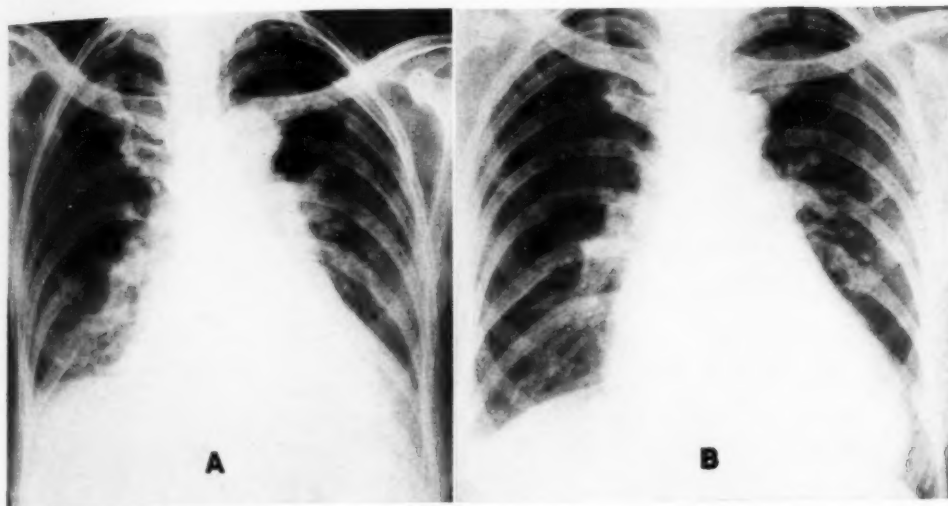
Pulmonary congestion. A. Roentgenogram with normal pressure. B. Roentgenogram with high pressure.
